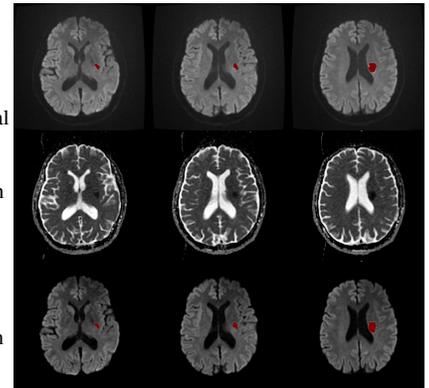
Top: Manual outline of stroke lesion overlaid on isotropic DWI. Middle: concomitant ADC map. Bottom: automatic segmentation by NB algorithm
